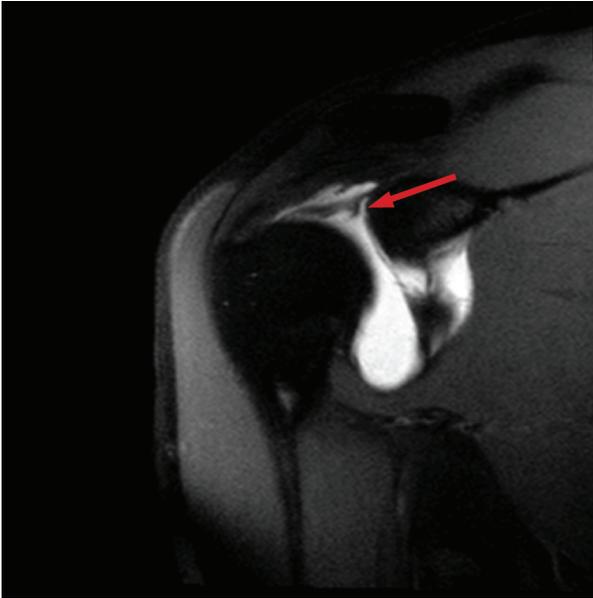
Coronal T2-weighted magnetic resonance imaging scan demonstrating a SLAP lesion with extension of contrast material between the glenoid and superior labral complex (arrow).
